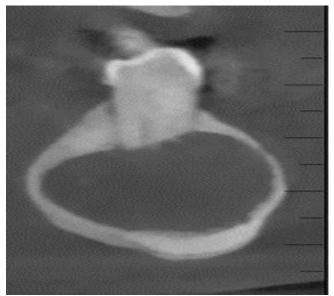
Radiographic View of Root Resorption with Regards to 34
